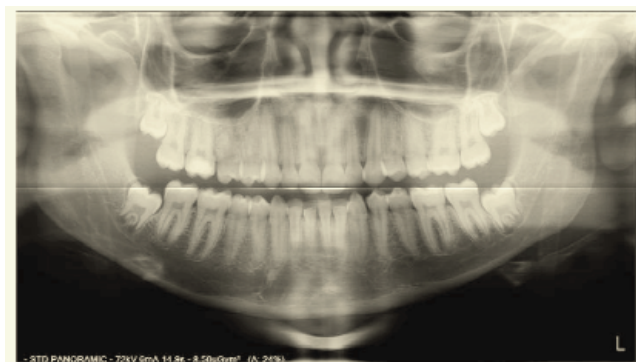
Dental panoramic radiograph.
